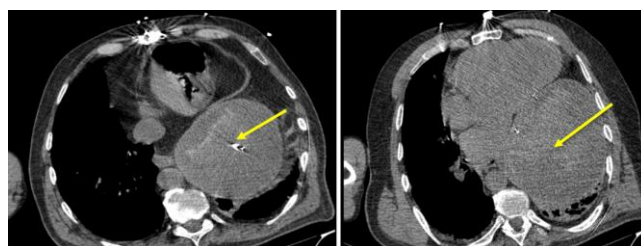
CT image of the patient before the operation. A mass lesion with calcification inside the left lower lobe pressing from the paravertebral sulci can be seen (yellow arrow), giving the image of an abscess, and with a semisolid appearance in places
